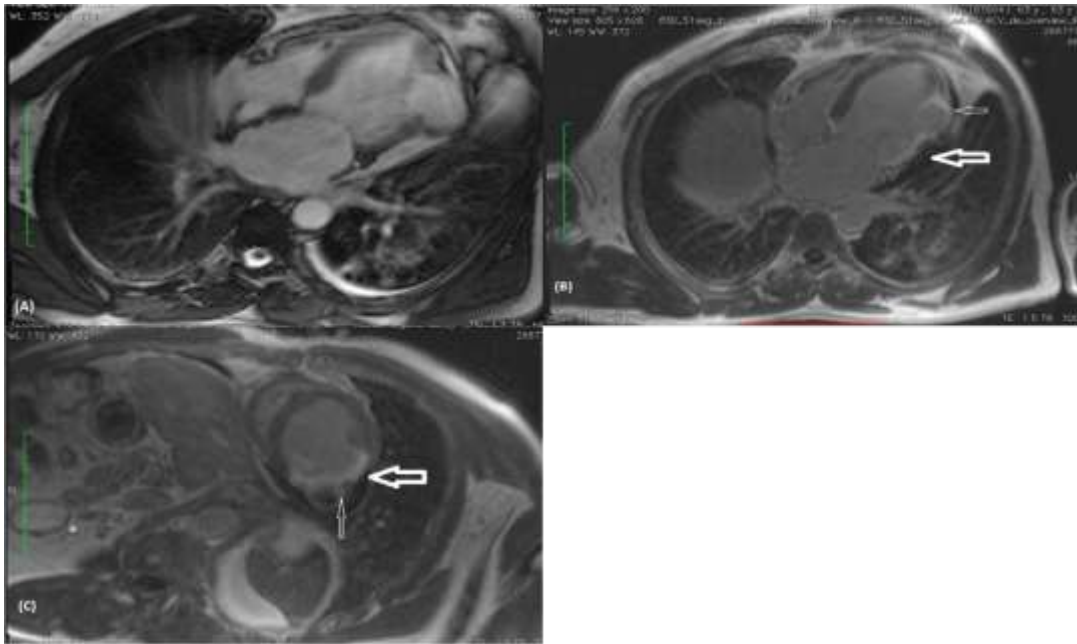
cardiac MRI: Cine four chamber view showing a large aneurysm formation (36 x 33 mm) with a wide neck (37mm) (A). Late gadolinium enhancement (LGE) in short apical four chamber view (B), and short axis view (C) showing a large aneurysm arising at the border between inferolateral and anterolateral wall segments, with full thickness LGE in its wall (small arrows) and pericardial effusion (large arrows)
